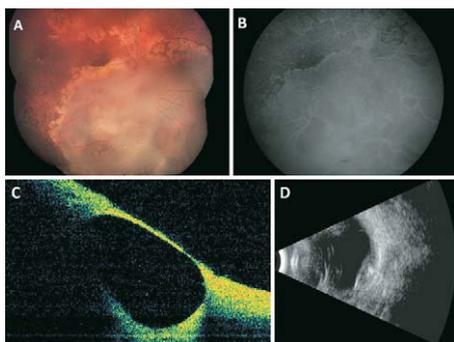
A 4-year-old boy with lazy eye presented with a giant spontaneously regressed retinoblastoma measuring 20 mm in diameter. (A) The large white retinal tumour showed numerous surface cavitory changes and surrounding retinal pigment epithelial alterations. (B) Fluorescein angiography showed looping random intrinsic vessels without leakage. (C) Optical coherence tomography demonstrated a surface cavity. (D) Ultrasonography showed a partially calcified retinal mass of 4.4 mm thickness.
